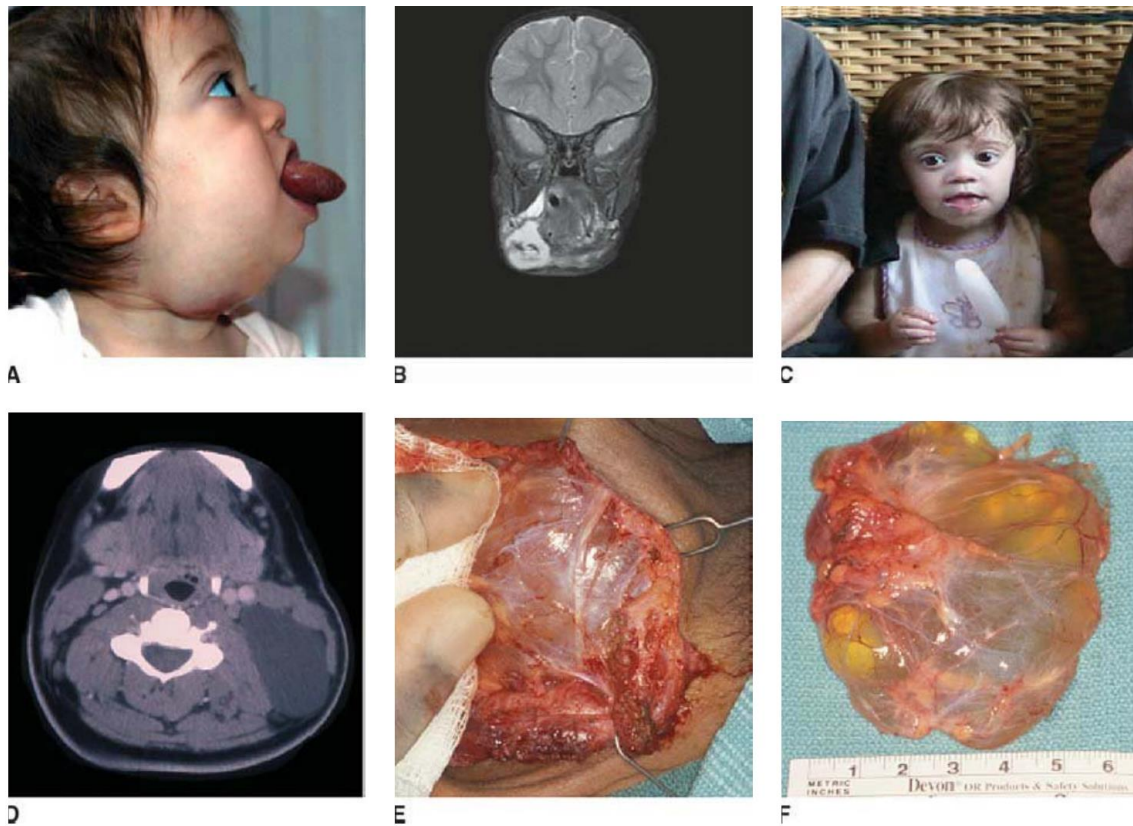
A: Combined microcystic and macrocystic malformation of the tongue, floor of mouth, and anterior neck. B: MRI with gadolinium of the same patient. C: Postoperative picture after excision of cervical disease and tongue reduction. D: CT scan of neck demonstrating macrocystic malformation of the lateral neck. E and F: intraoperative pictures demonstrating the appearance of a macrocystic lymphatic malformation.
